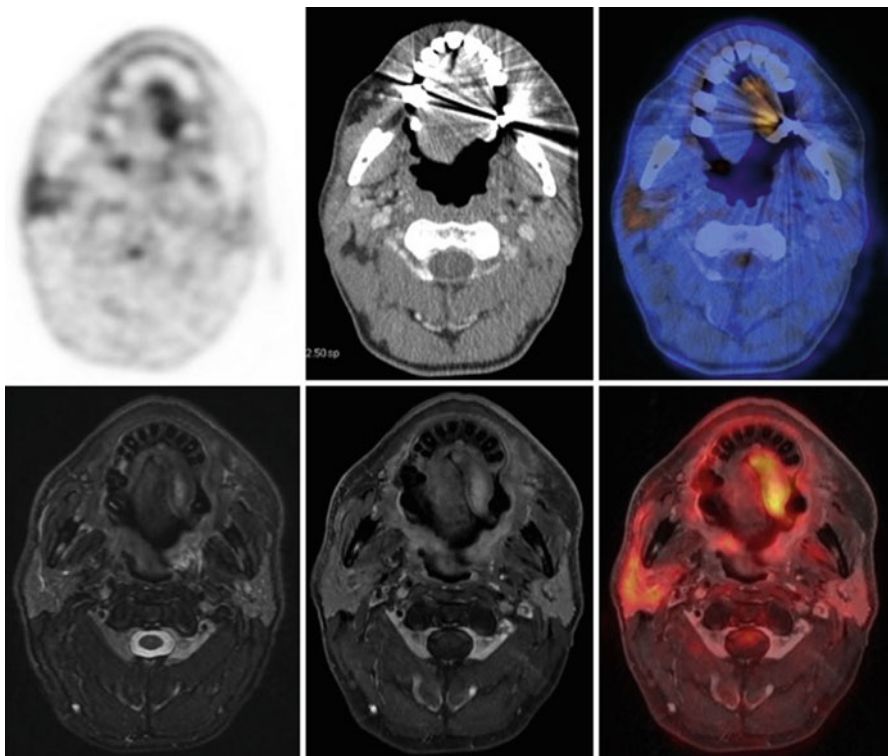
Base of tongue cancer on PET/CT (*top*) versus PET/MRI (*bottom*) [17]
